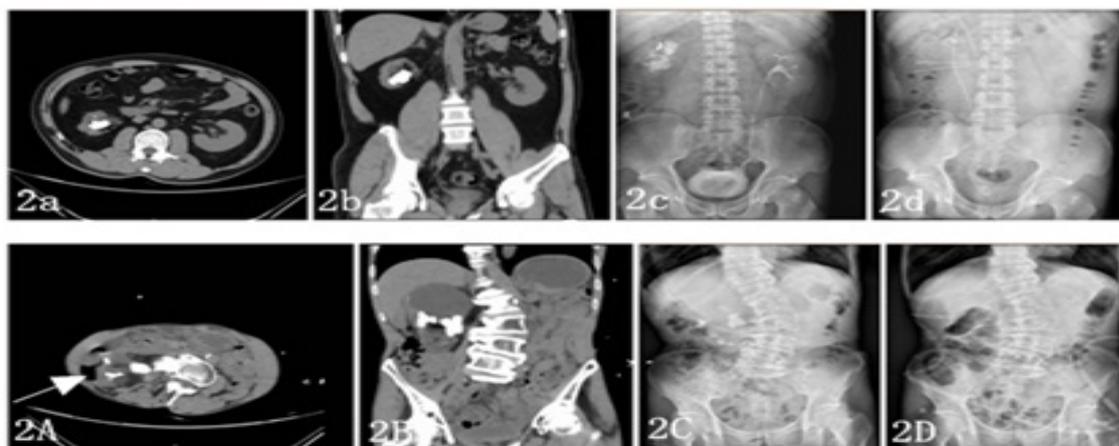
Patient A, Image pre-operation. (2A, 2B,) CT, arrows point to the posterior colon; (2c) KUB; post-surgery (2D) KUB.
